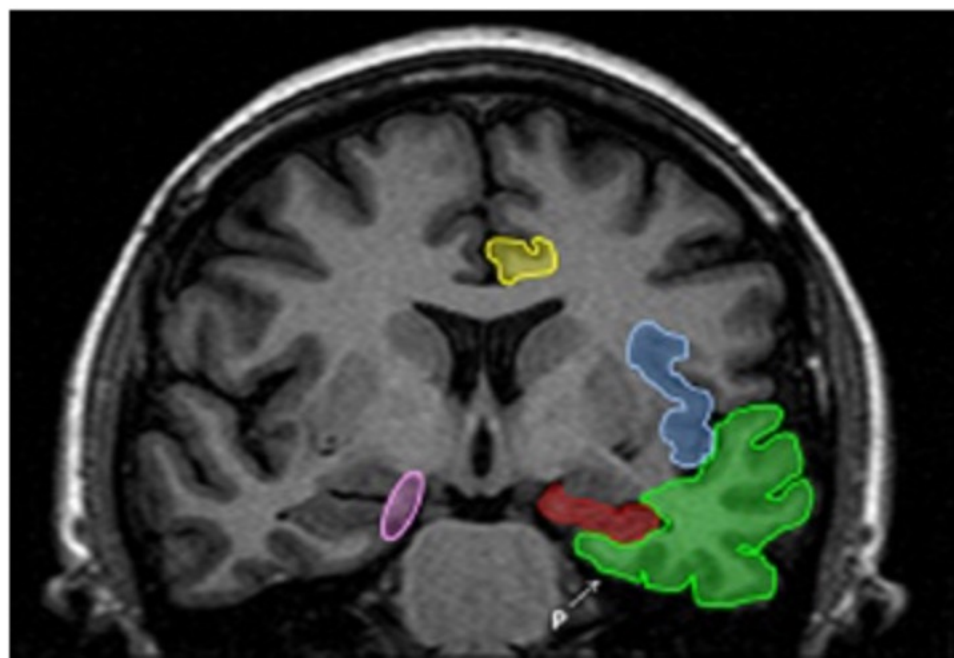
T1 weighted – IR (inversion recovery) coronal MRI. The structures most commonly involved of the limbic system in herpes encephalitis are identified (Yellow: cingulate gyrus; red: hippocampus; green: temporal lobe neocortex; blue: insula, pink: uncus; P: parahippocampal gyrus).
